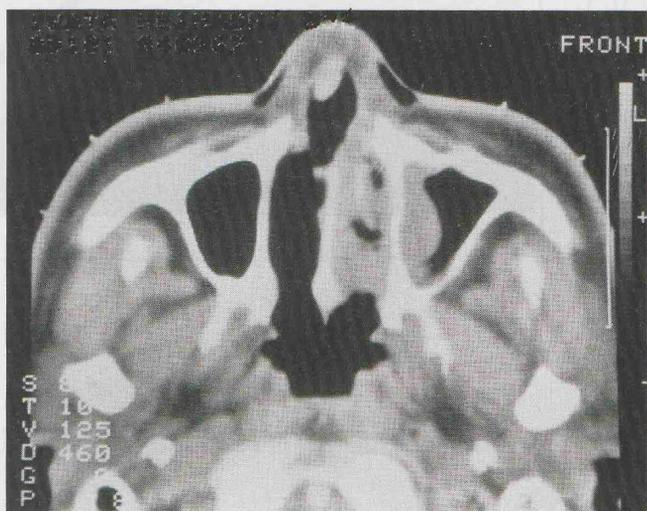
CT of case 2. A dense area of soft tissue in the nasal cavity with bone destruction was seen.
